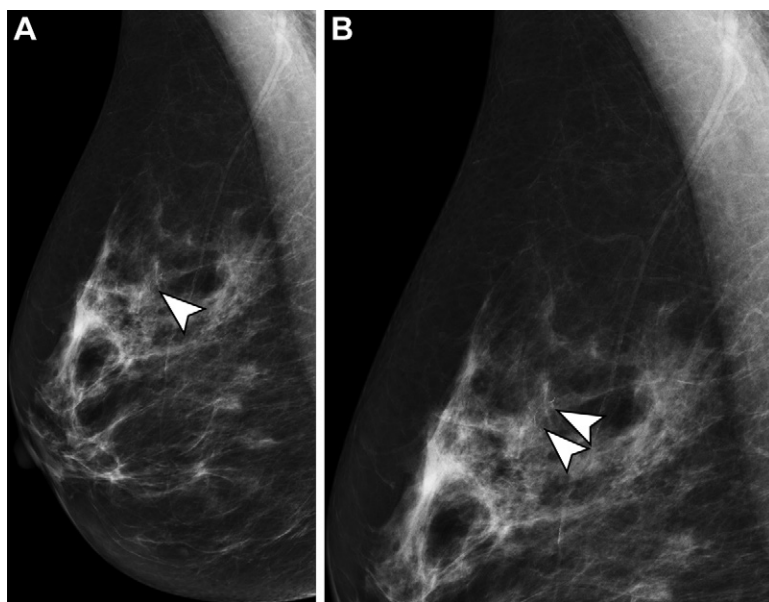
Mammograms in a 54-year-old woman undergoing her second screening mammographic examination. (A) There are 15 mm of pleomorphic microcalcifications (arrowhead) in the superior right breast on the mediolateral oblique view. (B) The microcalcifications (arrowheads) are best observed on this magnified view. It was not recalled by the radiographer who read the mammogram first and was recalled by the radiologist who read the image second. Stereotactic-guided biopsy showed high-grade ductal carcinoma in situ.
